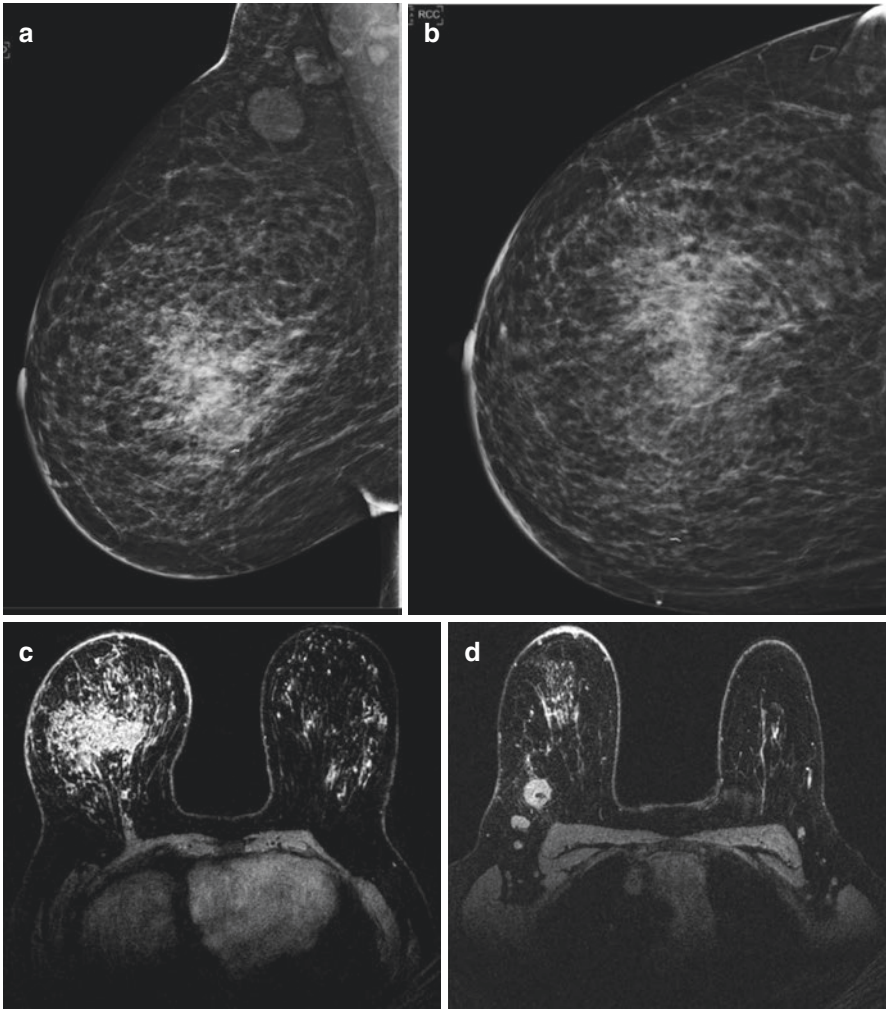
Mammogram. (a) Right MLO view. (b) Right CC view. (c, d) Axial fat suppressed T1-weighted post-contrast breast MRI images
